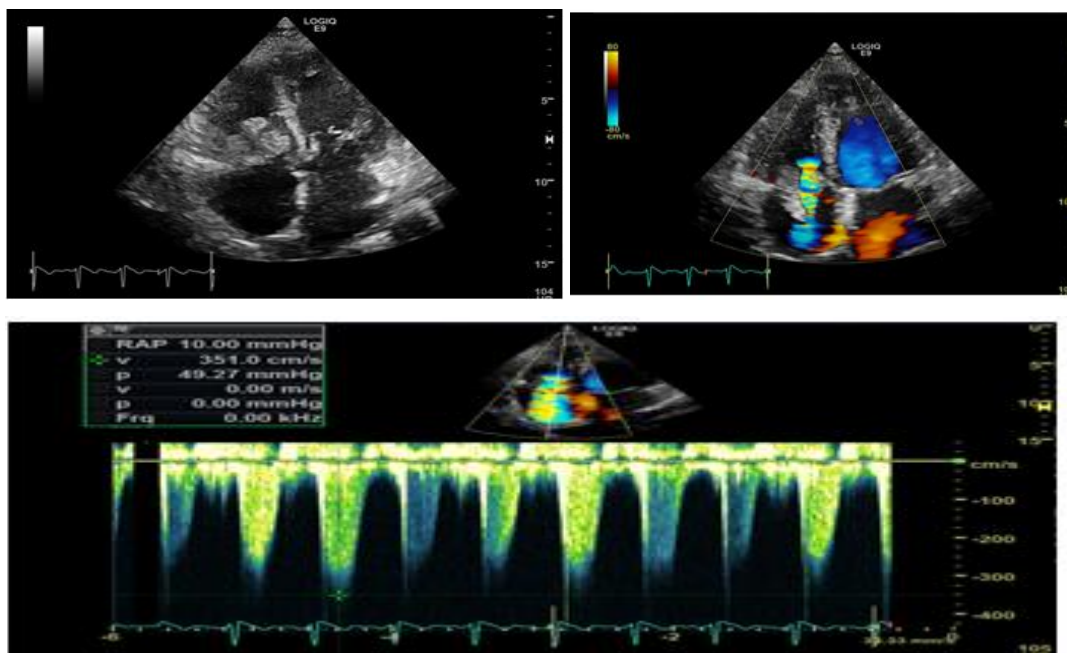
(Movie File 1 and 2): Follow up Transthoracic echocardiography showing : Large tricuspid valve vegetation (yellow arrow) sized 2.5 x 1.9 cm in the A) 4 chamber view, and also seen in the B) Color doppler shows severe tricuspid valve regurgitations and C) .
